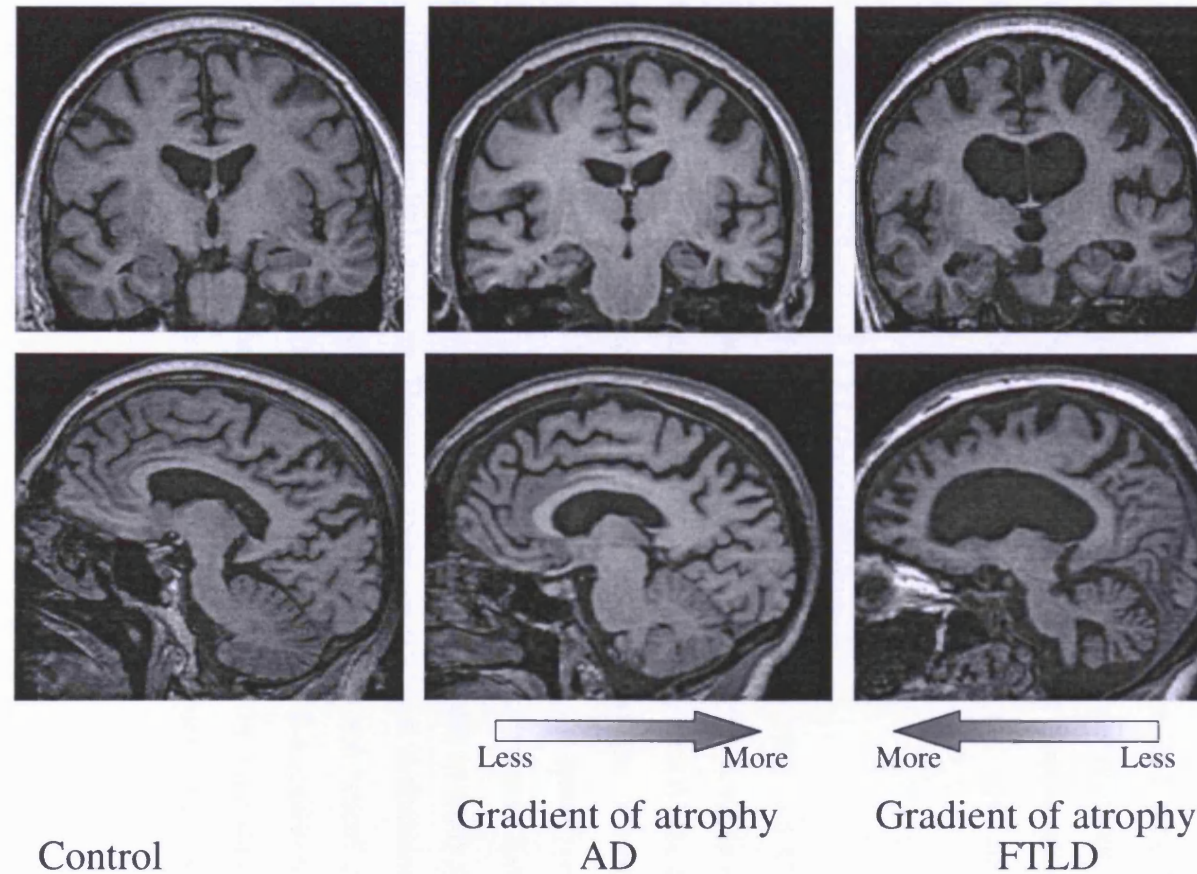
Cross-sectional MR images showing a normal control, an AD subject and an FTLD subject. AD is characterised by relatively small but symmetrical hippocampi. FTLD can present with either frontal or asymmetric temporal atrophy, the example shown is of an fvFTD subject. Differences between disease patterns are confounded by the large degree of inter-individual variability, for example this normal control has relatively large asymmetric ventricles.
